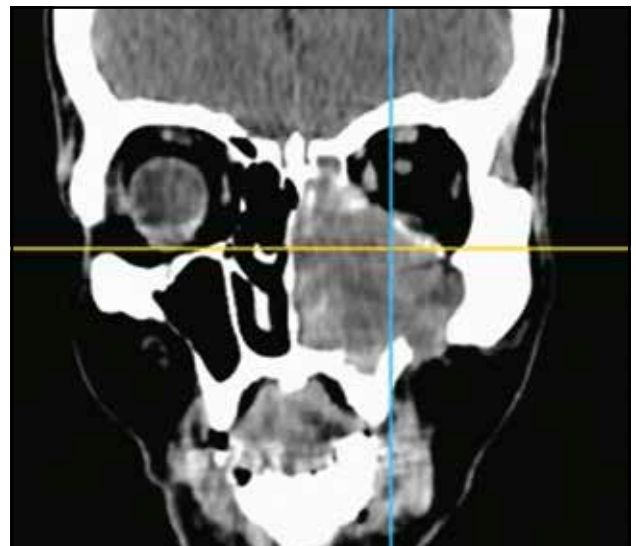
CT scan showing huge left midface and suprastructure tumor with lysis into the left orbital floor and in the maxillo-zygomatic pillar.
